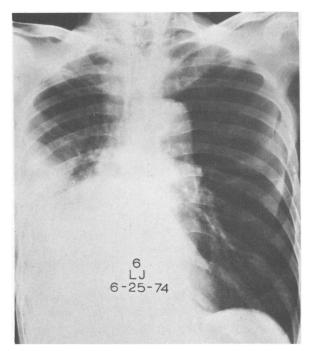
Roentgenogram of chest on 23rd hospital day showing reaccumulation of fluid following thoracentesis. Note absence of air in chest cavity and pericardium.
